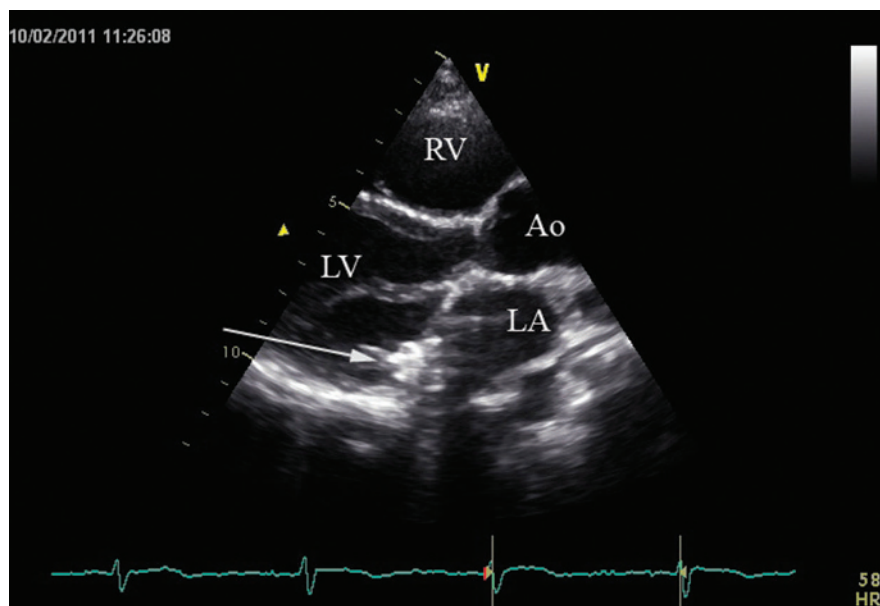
Sample transthoracic echocardiogram, parasternal long axis view. The Amplatzer™ Vascular Plug III (St. Jude Medical, St. Paul, MN) positioned in dehiscence (arrow). Ao, aorta; LA, left atrium; LV, left ventricle; RV, right ventricle.
